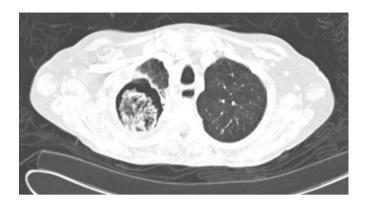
Chest computed tomography image showing a right upper lobe aspergilloma in a patient with sarcoidosis.
